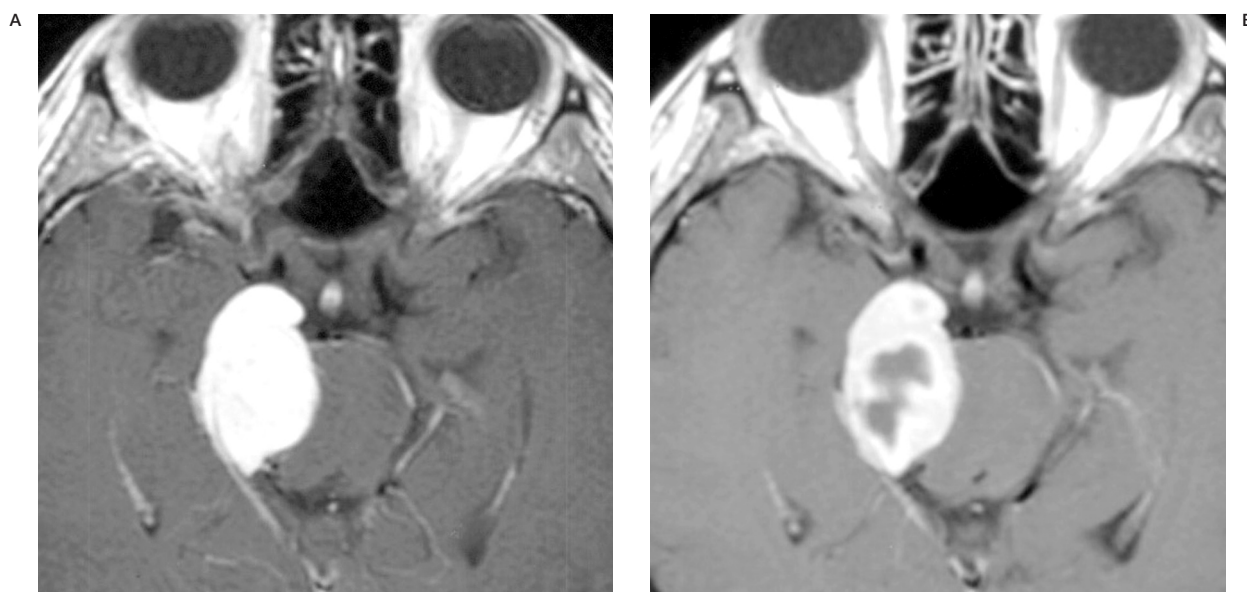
On MRI (left:pre-embolization, right: post-embolization) after embolization intratumoral necrotic change was identified.
